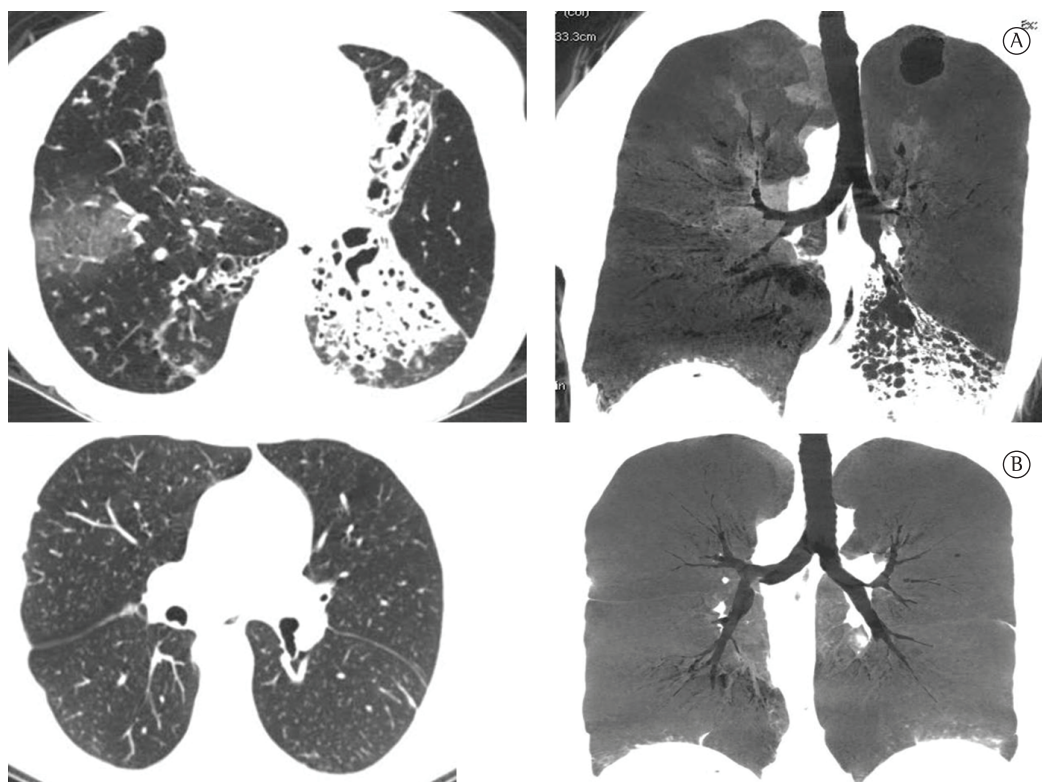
In A, preoperative chest CT scans showing areas of bronchiectasis. In B, chest CT scans taken two months after transplantation and revealing healthy lungs and no bronchiectasis.
